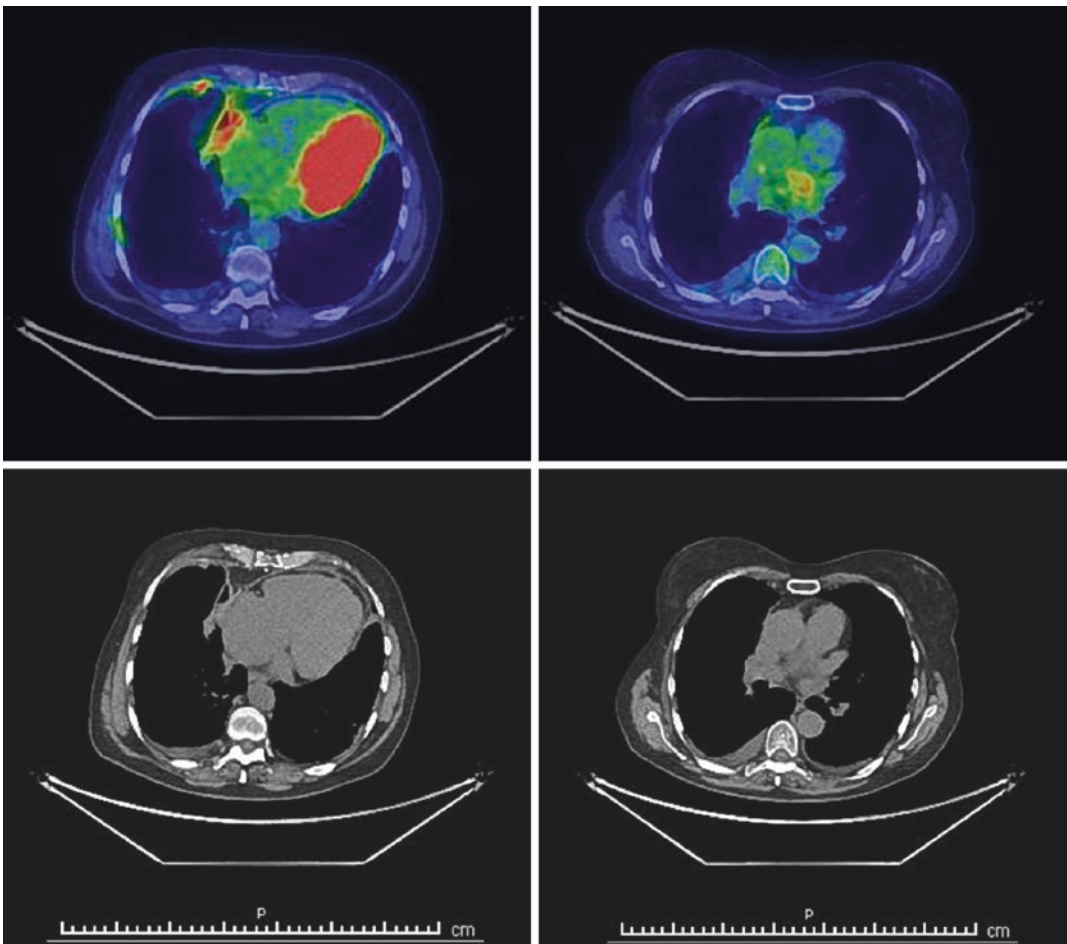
Positron emission tomography (PET) and computed tomographic (CT) imaging of a pericardial mesothelioma
